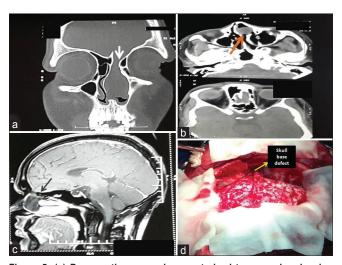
(a) Preoperative coronal computerized tomography showing defect in anterior cranial fossa with encephalocele. (b) Preoperative axial computerized tomography showing ethmoid defect with encephalocele (orange arrow). (c) Preoperative sagittal magnetic resonance imaging showing defect in orbital roof (thick black arrow indicates the defect). (d) Bifrontal craniotomy showing the anterior cranial fossa defect with traversing encephalocele sac
